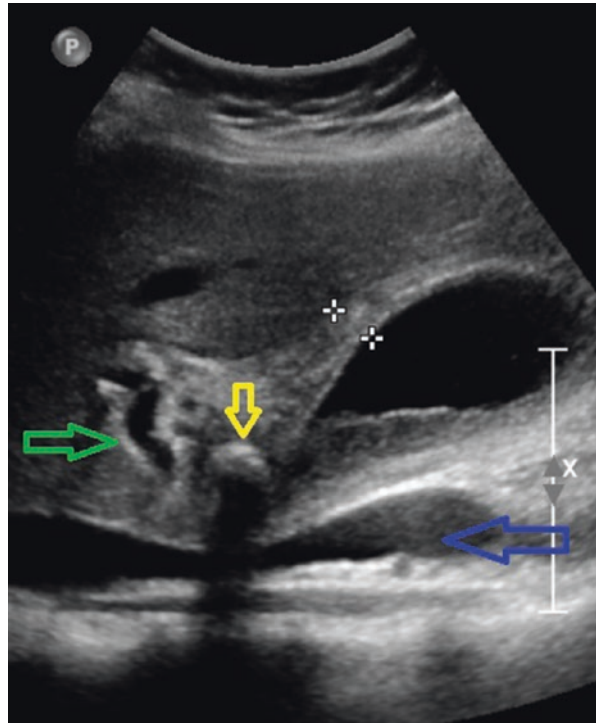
A 28-year-old woman was 6 weeks post-partum with acute cholecystitis clinically and a mild elevation of LFT. The ultrasound demonstrated a stone impacted in the gallbladder neck/cystic duct (yellow arrow) with associated gallbladder wall oedema and sludge. The stone is close to the common hepatic duct with mild dilation (green arrow). The posterior structure (blue arrow) is the portal vein. At LC a type I Mirizzi syndrome was confirmed
